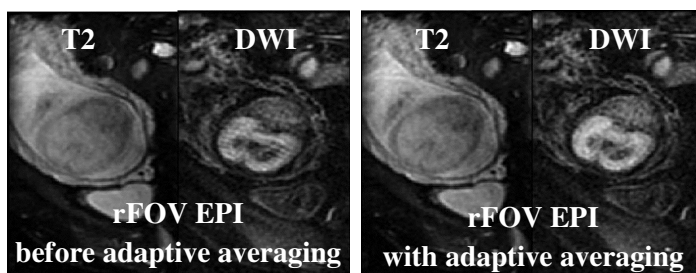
Motion artifacts in rFOV image-set (slight blurring in T2, strip artifact in combined DWI) have been mostly removed by retrospective application of the adaptive averaging technique.
